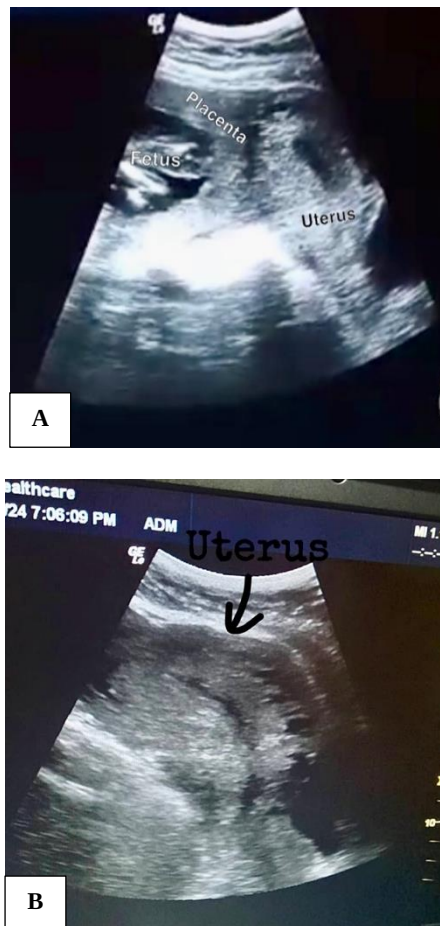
(A) Ultrasound scan at admission; (B) empty uterus on ultrasound scan.
